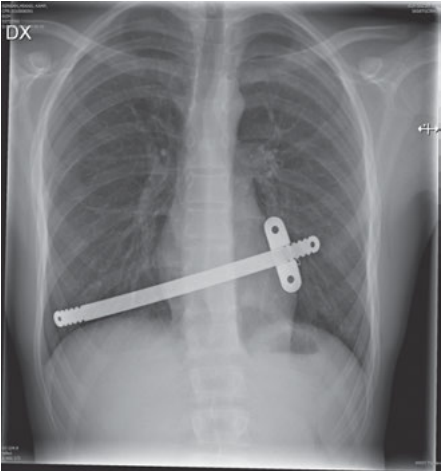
The X-ray shows an oblique bar.
